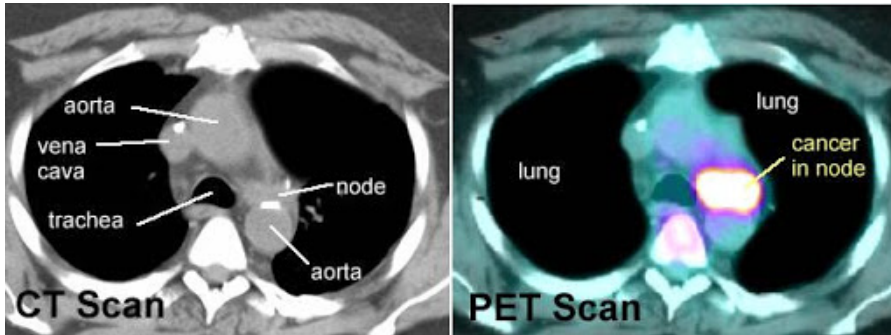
CT and PET images of a cancerous lung [18]
